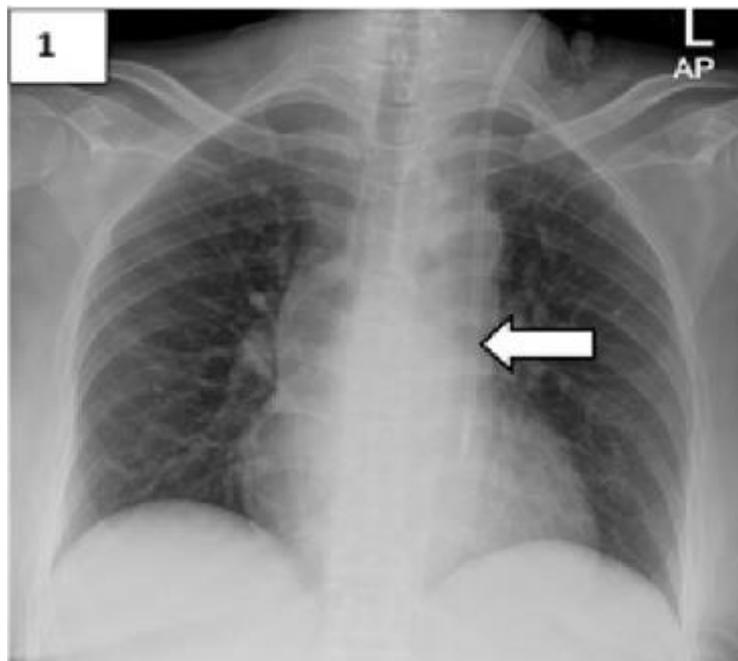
Chest radiograph revealed the position of the catheter tip on the left mediastinum (white arrow)
